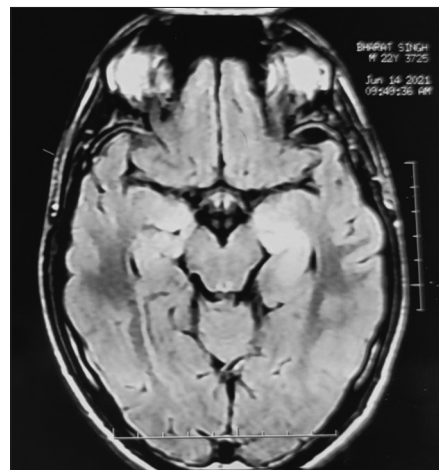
MRI brain T2 FLAIR showing bilateral medial temporal lobe hyperintensity
